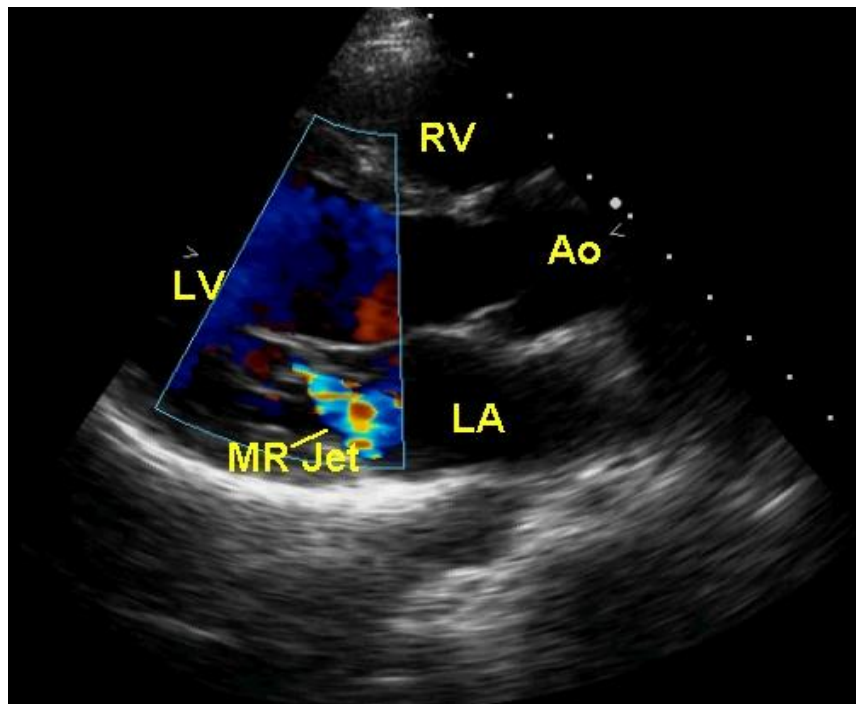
Colour Doppler echocardiogram in parasternal long axis view showing mitral regurgitation (MR jet), the heart cavities: left ventricle (LV), left atrium (LA), right ventricle (RV) and aorta artery (Ao).[1]
